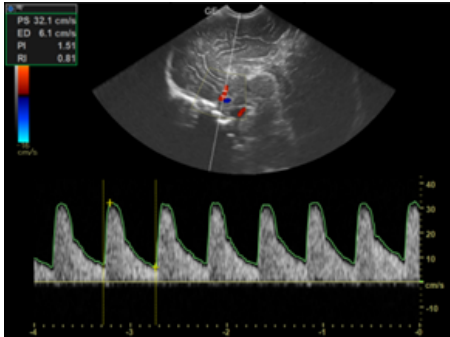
B-mode image with spectral doppler analysis of ACA after localization of the vessel in the sagittal plane of healthy term neonatal brain.
